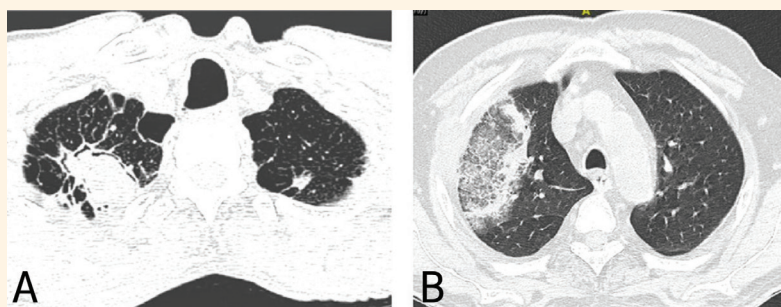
Computed tomography of (A) a 70-year-old male patient showing a thick-walled cavity in the right upper lobe with an intracavitary mass surrounded by a crescent of air known as the 'air crescent sign' (case one) and (B) a 65-year-old male patient showing central ground-glass opacity surrounded by a complete ring of consolidation known as the 'reverse halo sign' (case two).
